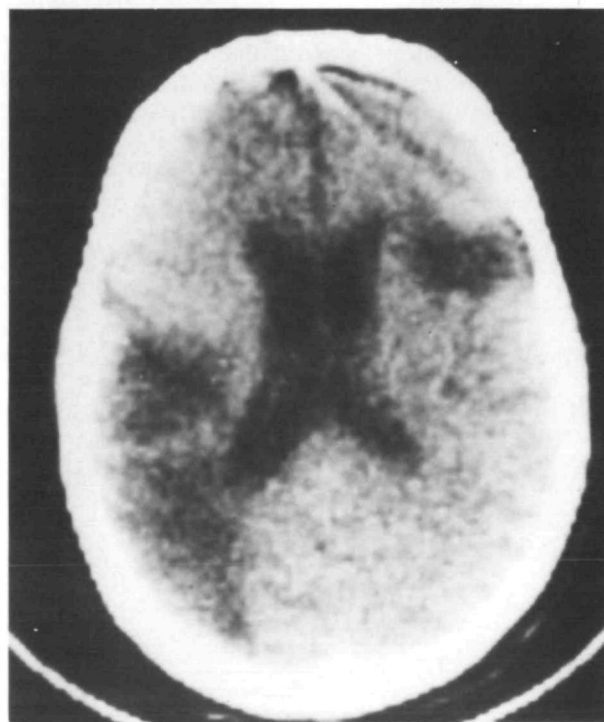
CT of patient 1 (DG) demonstrating multiple low density areas consistent with cerebral infarction.
